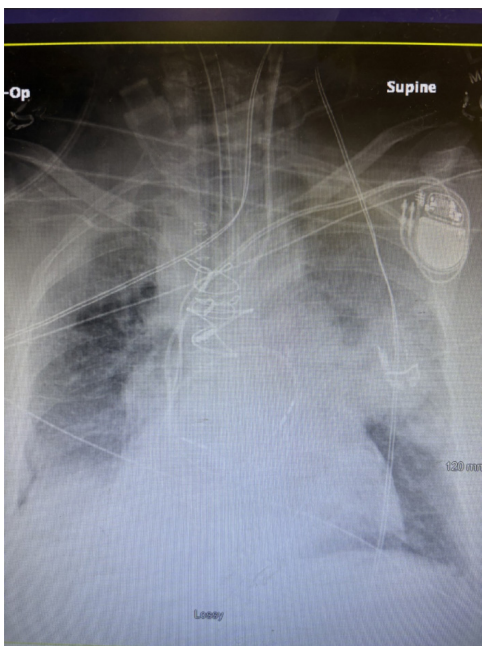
Chest radiograph obtained on the day of admission.
